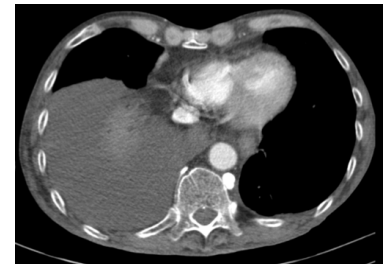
Chest CT scan showing large left pleural effusion (white arrow).
